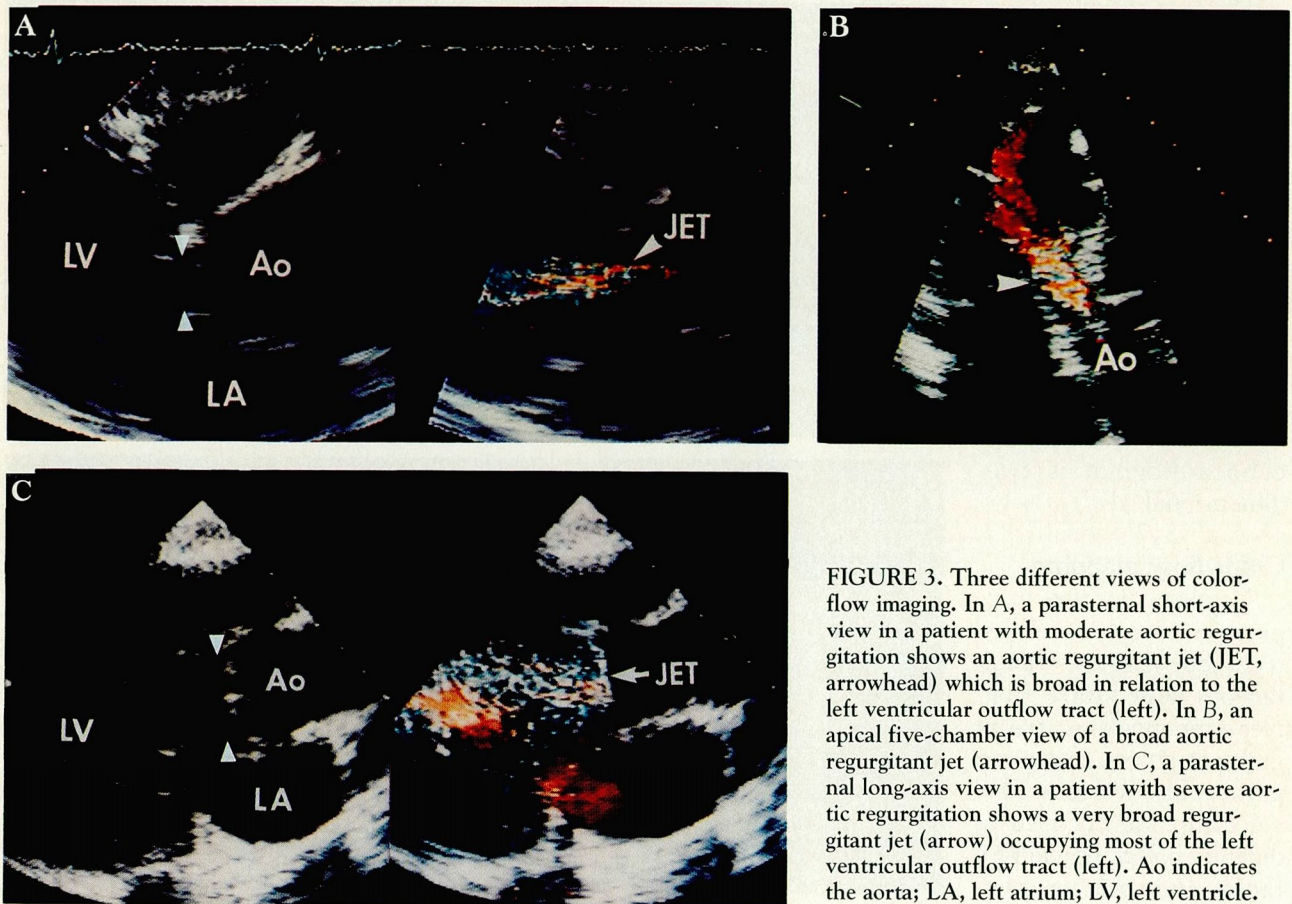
Three different views of color-flow imaging. In A, a parasternal short-axis view in a patient with moderate aortic regurgitation shows an aortic regurgitant jet (JET, arrowhead) which is broad in relation to the left ventricular outflow tract (left). In B, an apical five-chamber view of a broad aortic regurgitant jet (arrowhead). In C, a parasternal long-axis view in a patient with severe aortic regurgitation shows a very broad regurgitant jet (arrow) occupying most of the left ventricular outflow tract (left). Ao indicates the aorta; LA, left atrium; LV, left ventricle.
